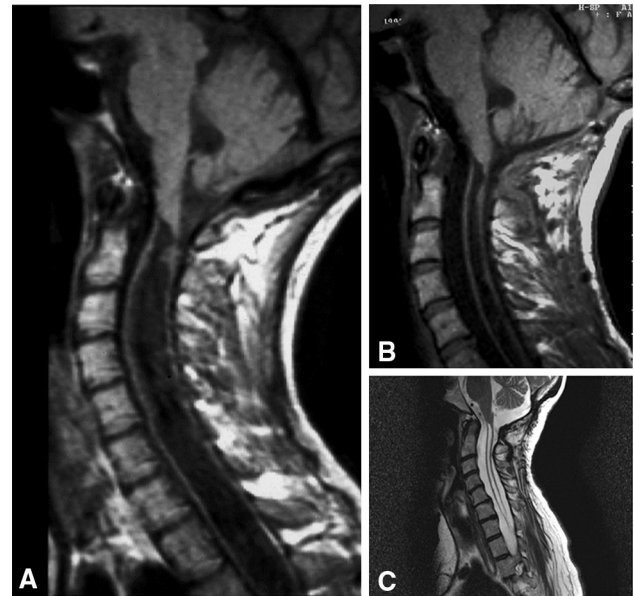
T1-weighted sagittal MR image showing chambered syringomyelia with the upper level at C1 (a). The syrinx presents initial collapse at the first follow-up after 3 months (b). Two years later, further and definitive collapse of the syrinx can be seen (c)
